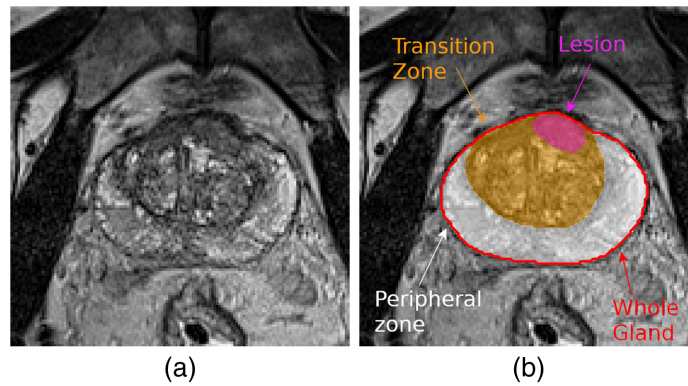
(a) Axial view of the T2-weighted MR image of a prostate. (b) The corresponding zonal and lesion segmentation. The WG is the union of TZ and PZ.
